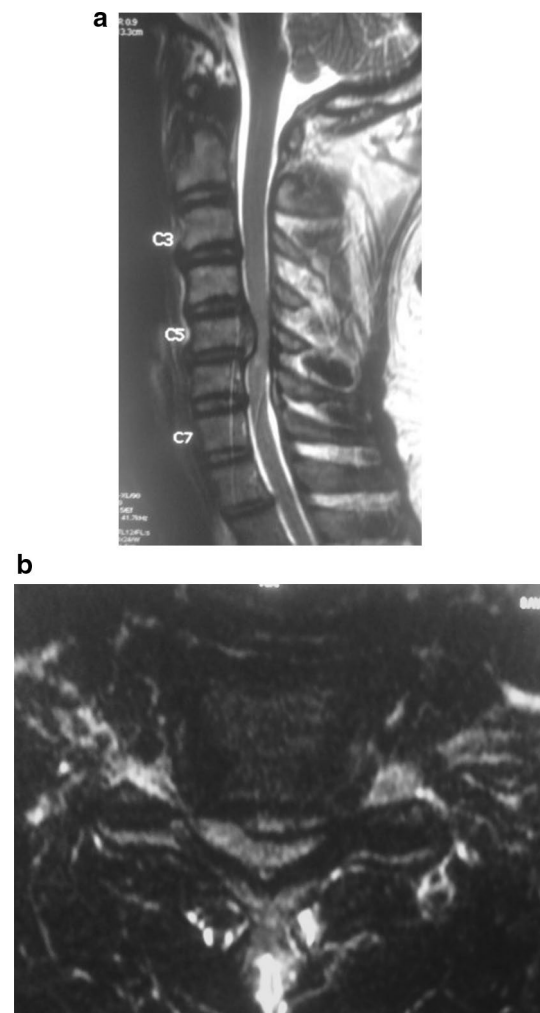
a Sagittal MRI demonstrating significant spinal cord compression posterior to the C5 body. b Axial MRI section showing disc herniation with significant spinal cord compression posterior to the C5 body
